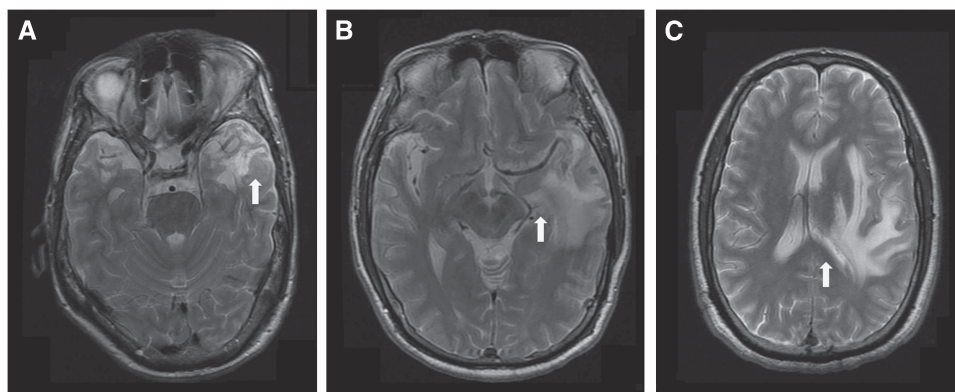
Axial T2-weighted magnetic resonance images showing the severity of local mass effects. (A) Mild local mass effect affecting only the sulci of the temporal lobe (white arrow). (B) Moderate local mass effect affecting the sulci and ventricle (white arrow). (C) Severe local mass effect affecting the midline (white arrow).
